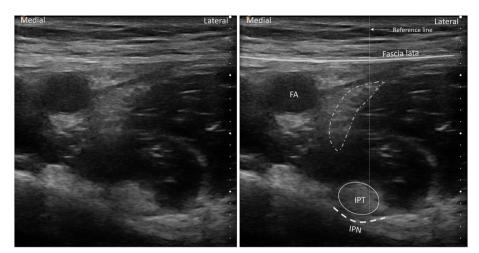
Ultrasound image of a 17-year-old girl 54 kg in weight and 163 cm in height. The reference line passes over the femoral nerve. FA: femoral artery, FN: femoral nerve, IPN: iliopsoas notch, IPT: iliopsoas tendon
